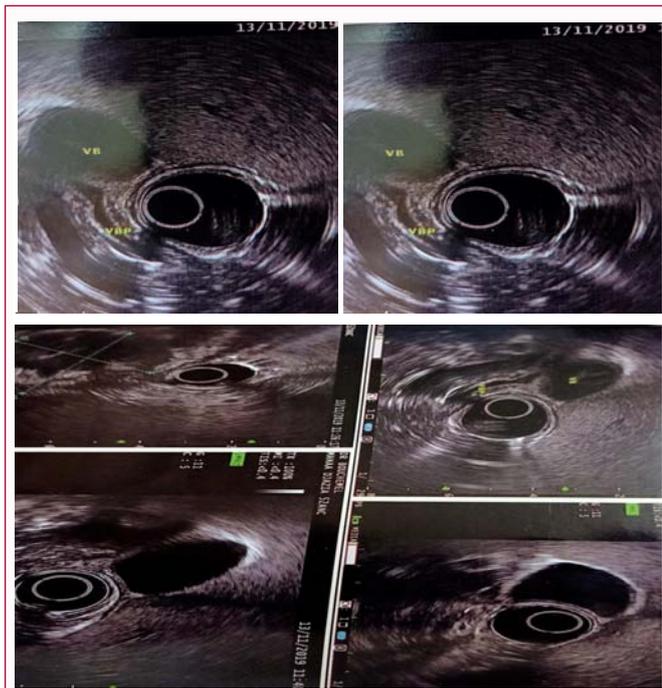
Endoscopic Ultrasound showing cholesterosis of gallbladder (VB) with empty CBD (VBP) associated with big collection near the stomach.
